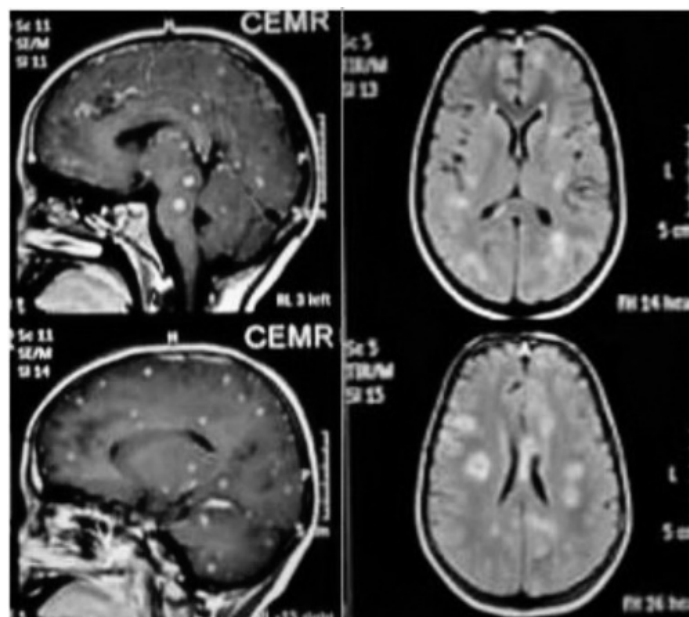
MRI of brain showing multiple lesions with enhancement (Starry sky appearance).
